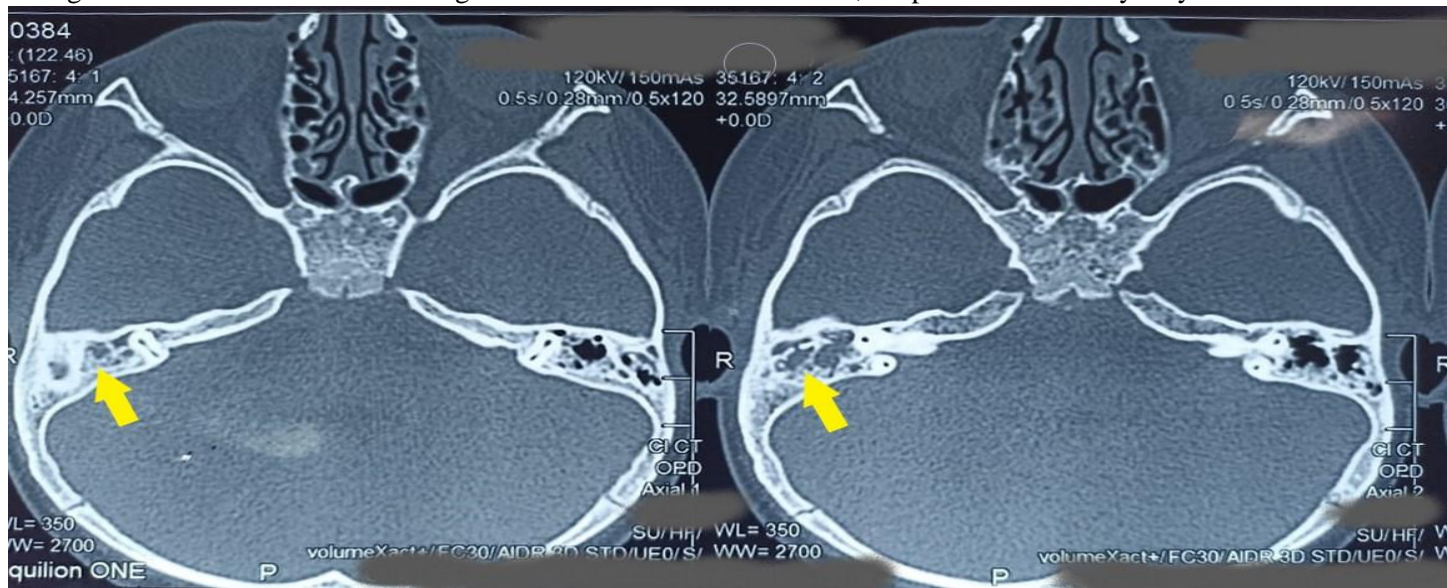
Incipient Mastoiditis: Acute otitis media with acute mastoiditis as CT Temporal bone axial view shows opacification of right middle ear cavity with loss of pneumatization of mastoid air cells on the right sides. However, the fluid is contained within the cavities. Ossicles and osseous walls of mastoid and middle ear cavity are intact. Per-operative findings include glue ear and serous fluid with negative pressure entrapped in the mastoid cavity
